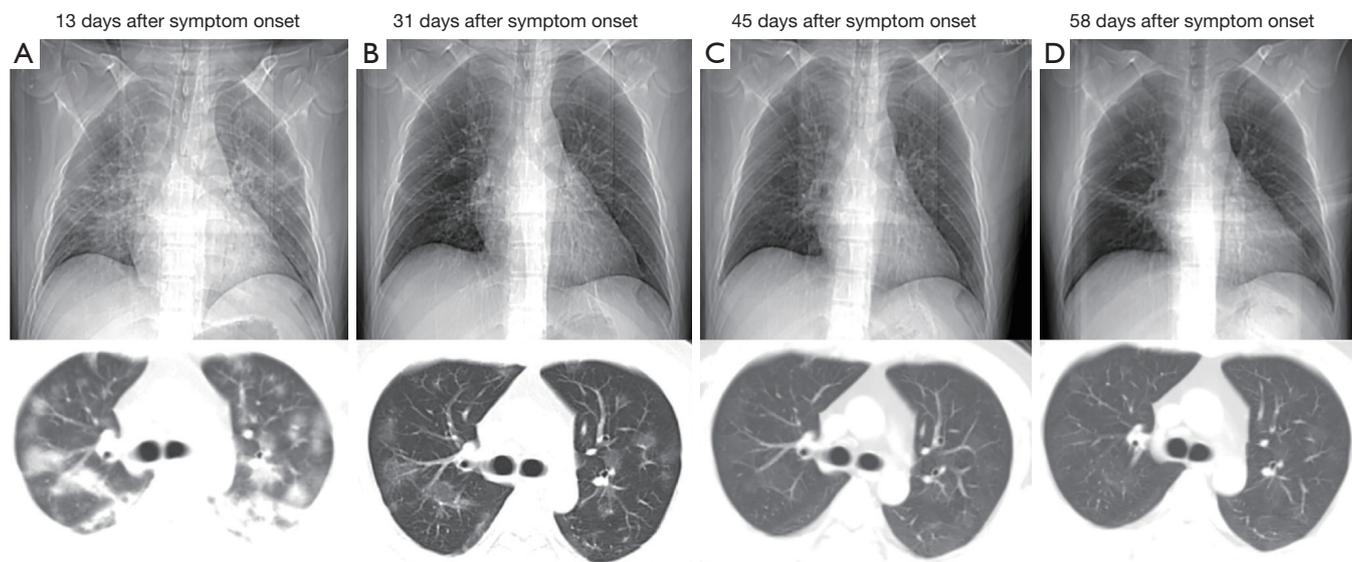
Representative chest computed tomographic images of a 32-year-old male patient with severe COVID-19 in different stages. (A) Image obtained on day 13 after symptom onset shows multiple patchy GGO and consolidations in bilateral lungs. (B) Image obtained on day 31 after symptom onset shows GGO, and consolidation are obviously resolved in bilateral lungs. (C,D) The lesions were gradually absorbed later from day 45 (C) and day 58 (D). COVID-19, coronavirus disease 2019; GGO, ground-glass opacities.
